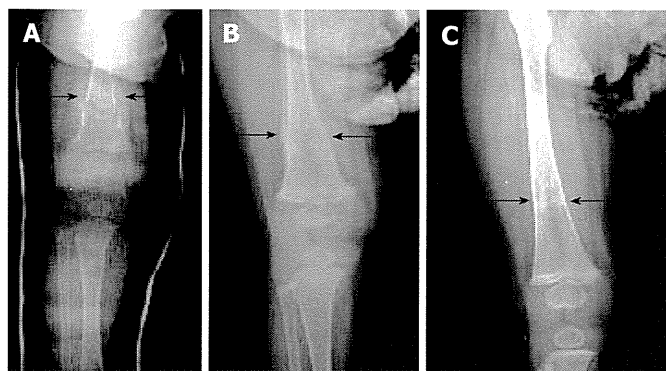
Plain skeletal radiographic features at the 8 d after the application of an immobilizing plaster bandage for the femur fracture in the case 1. Callus formation (arrows) was seen 8 d after the application of an immobilizing plaster bandage (A) in case 1. The plaster bandage was removed after 20 d (B) and the fracture of the right femur was cured 6 mo post-fracture (C).
